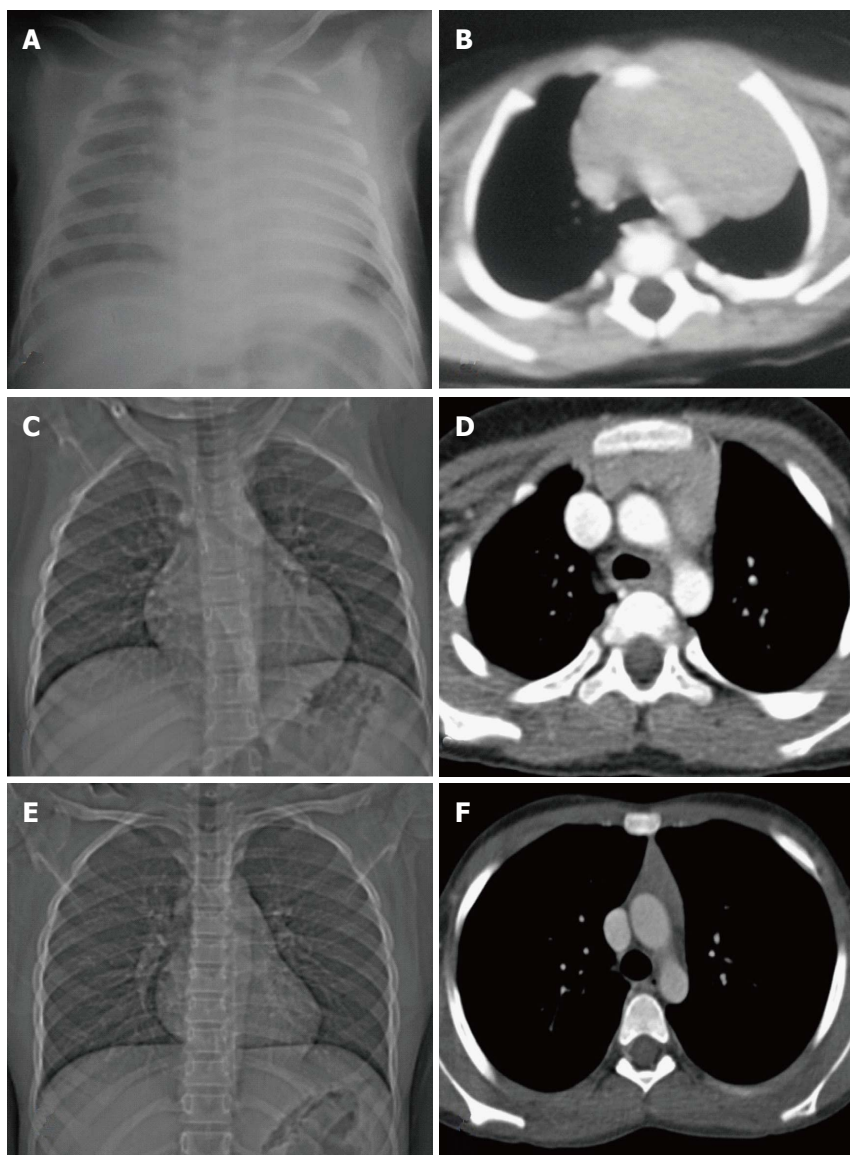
Normal variation in the appearance of the thymus with age. Frontal radiographs and CECT axial images at ages of (A, B) 2 mo, (C, D) 7 years and (E, F) 12 years. Note that the initial prominent bilobed thymus in a neonate assumes a quadrilateral shape with convex margins in early childhood. Gradually it assumes a triangular configuration with straight margins. The CT density also decreases with age with fatty replacement occurring in adults.
